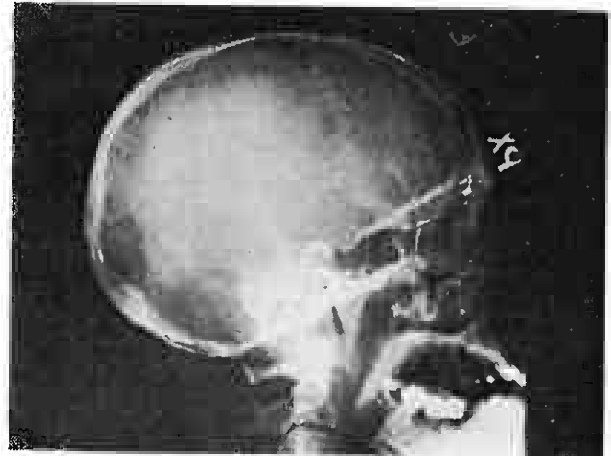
Straight X-ray skull.
